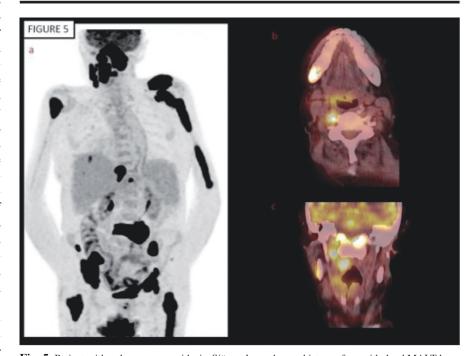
Patient with pulmonary sarcoidosis, Sjögren's syndrome, history of parotid gland MALT lymphoma and L4 pathological fracture. FDG PET scan was done and demonstrated hepatic and bone dissemination: a) whole-body scan, b) axial and c) coronal images. Bone marrow biopsy disclosed T-cell lymphoma. No pathological hypermetabolism was seen in salivary glands.
